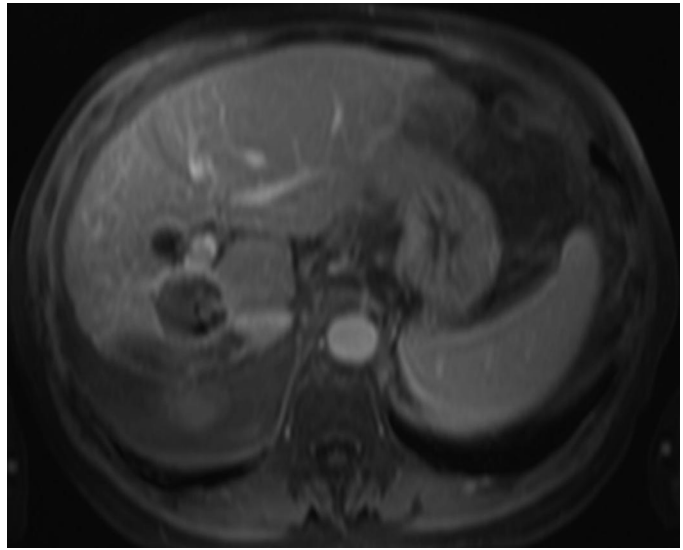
Contrast material–enhanced MR image demonstrates a 5.6-cm × 5.1-cm mass in caudate lobe.
